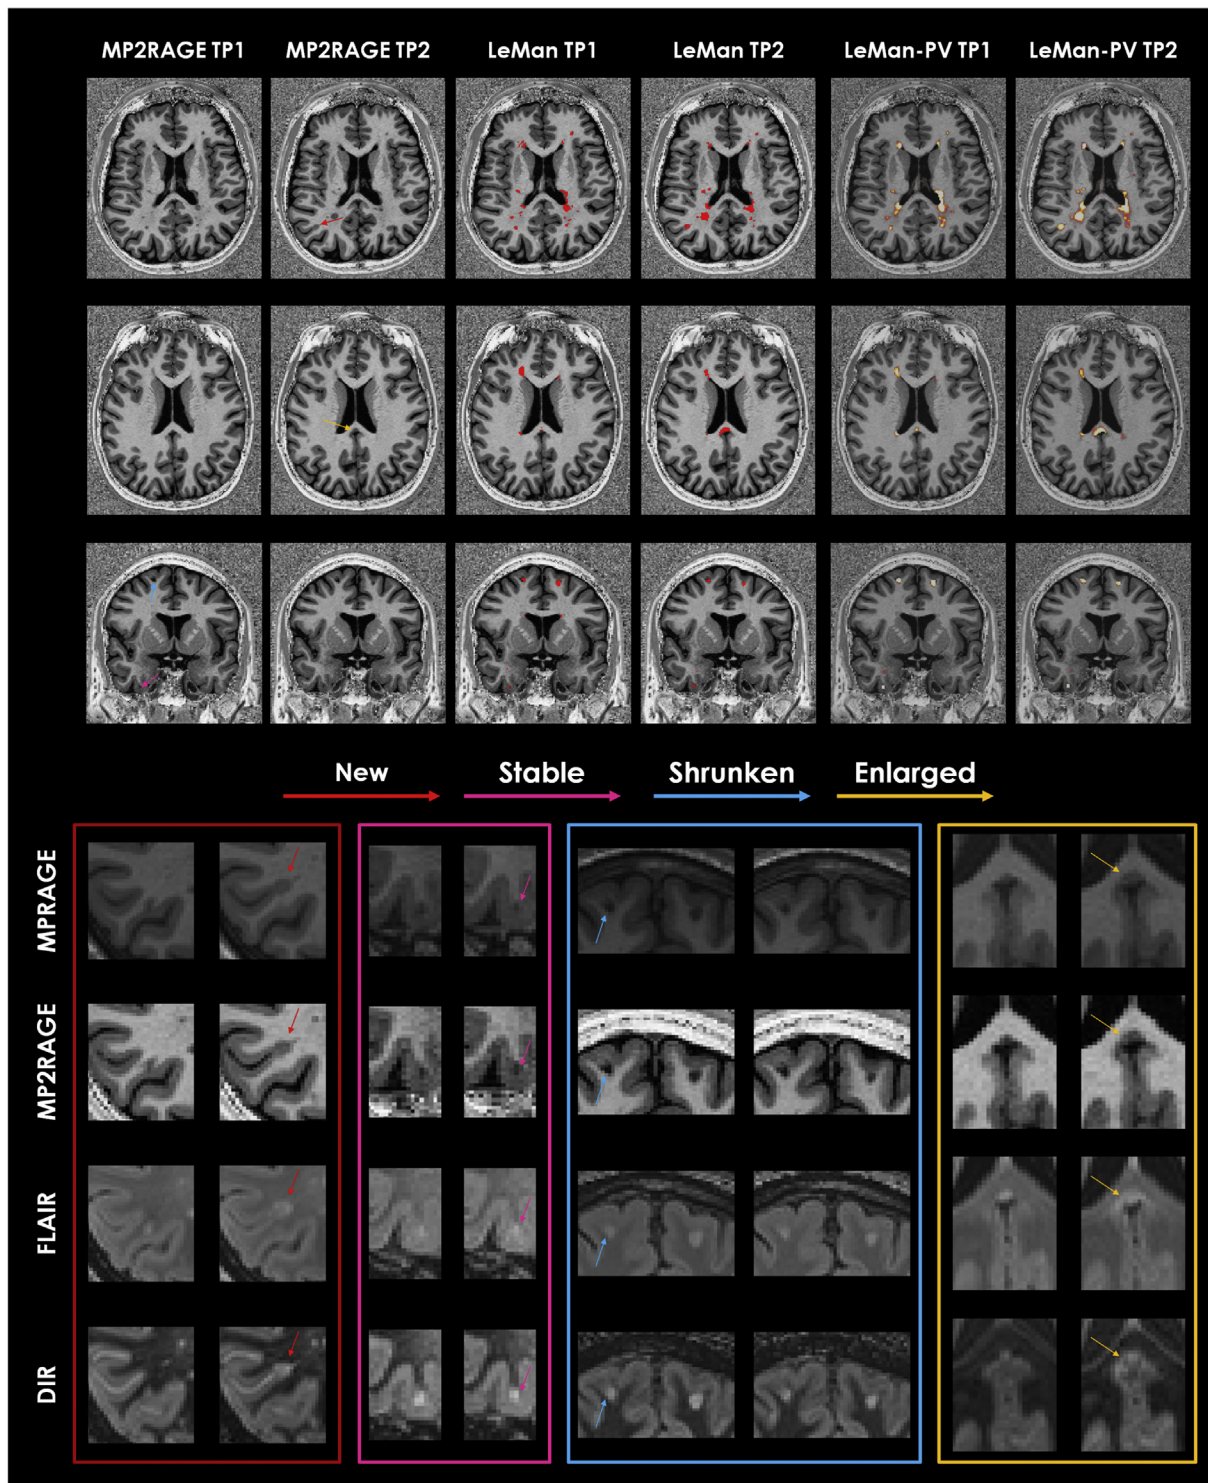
From top to bottom: Axial MP2RAGE image in a 24-year-old woman; Axial MP2RAGE image in a 35-year-old man; Coronal MP2RAGE image in a 33-year-old man. All cases are relapsing-remitting MS. MP2RAGE images are shown for the registered time point 1 (TP1) and the respective time point 2 (TP2). Results from algorithm before (LeMan) and after (LeMan-PV) applying the partial volume model using the non-conventional protocol are shown in the 3rd-4th and 5th-6th columns, respectively. The output of LeMan is a binary mask and the output of LeMan-PV is a concentration map. Examples of new, stable, shrunken, and enlarged cortical lesions are indicated with red, pink, blue, and yellow arrows, respectively. Patches of the zoomed area of the different lesion categories in each image contrast (MPRAGE, MP2RAGE, FLAIR, and DIR) are shown at the bottom. (For interpretation of the references to color in this figure legend, the reader is referred to the web version of this article.)
